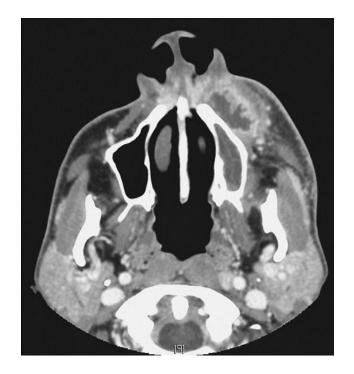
Contrast-enhanced CT scan of a focal, ring-enhancing infraorbital abscess with an irregular (scalloped) contour of the abscess wall.
